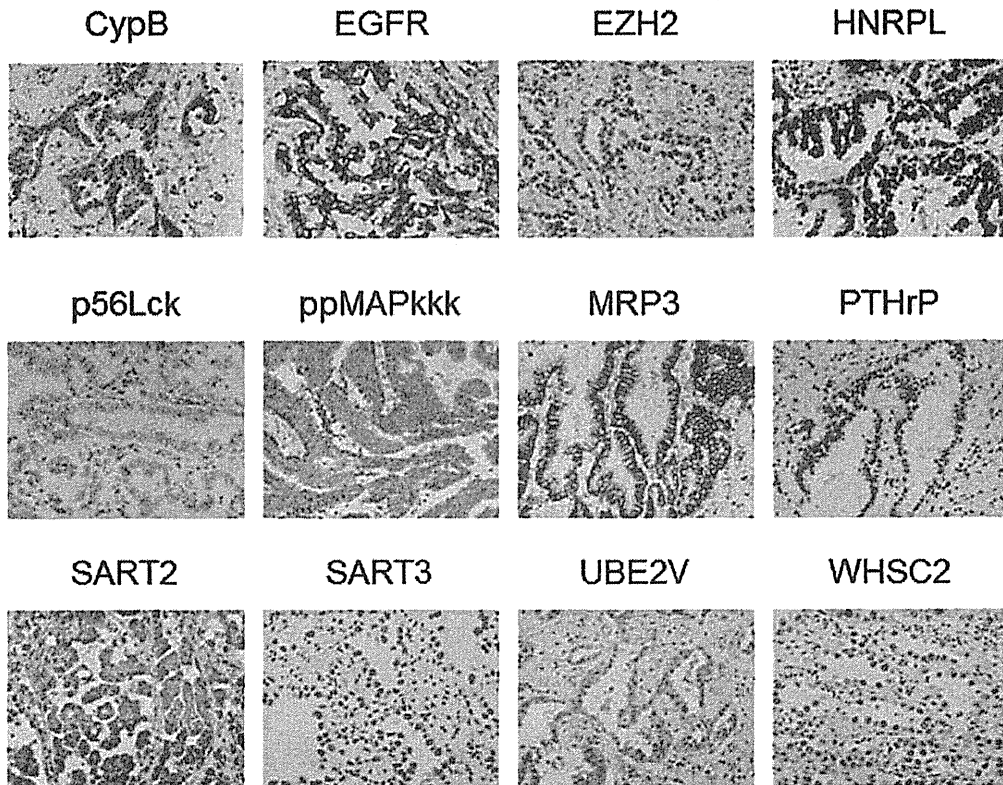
Expressions of vaccine antigen in lung adenocarcinoma tissues. Expression of 12 vaccine antigens, from which the peptides were derived, was examined by IHC in primary cancer tissues of 10 non-vaccinated lung adenocarcinoma patients. Representative results are shown (x400). The data of three prostate-related antigens, PAP, PSA and PSMA, are not shown.
